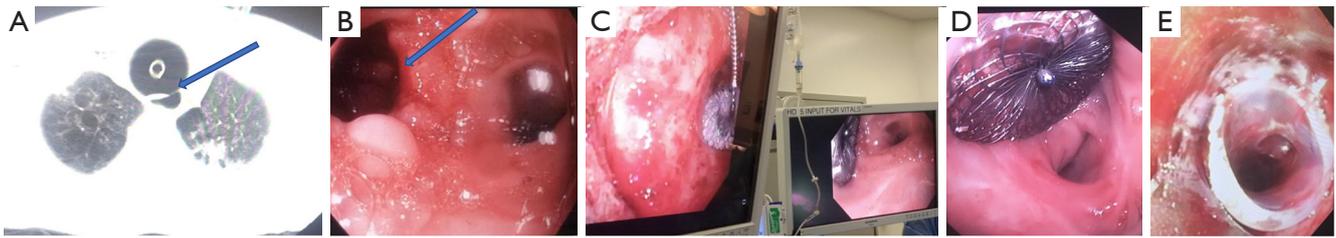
A case of benign TEF caused by endotracheal tube cuff overinflation, managed with an ASD occluder size 23–10–18 mm. (A) CT of the chest with dilated trachea and visible TEF fistula (blue arrow). (B) Endoscopic view from the esophagus with visible TEF (blue arrow). (C) Bronchoscopic view (left) and endoscopic view (right) during placement of the ASD occluder. (D) Endoscopic view post ASD occlude placement. (E) T-tube stent placed on top of the ASD occluder device causing minimal airway lumen compromise (case report and images are courtesy of Dr. Eugene Shostak). ASD, atrial septal device; CT, computed tomography; TEF, tracheoesophageal fistula.
